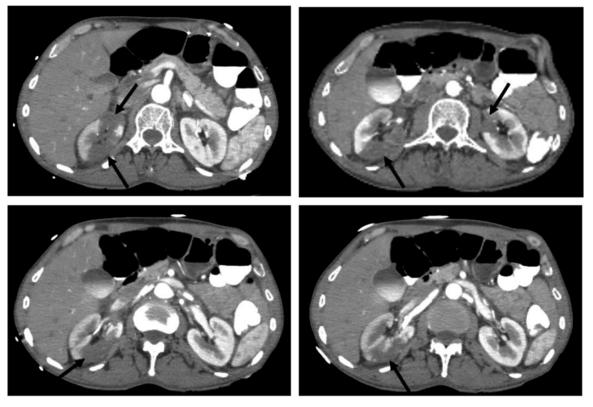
CT angiogram of the abdomen reveals bilateral renal infarcts (arrows) that are predominant on the right side.
